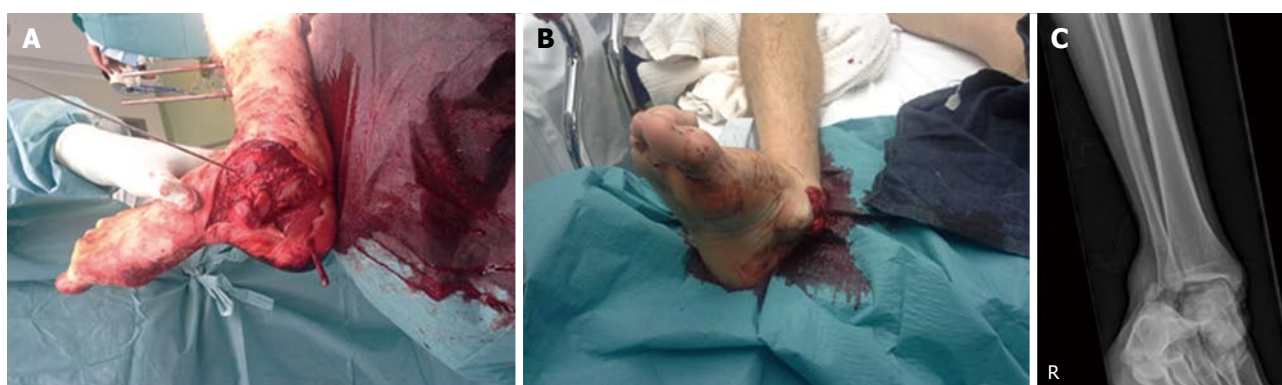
Initial trauma screening revealed a hemodynamically stable patient with a complicated (Gustilo type 3) subtalar joint dislocation of the right leg. A and B: Gustilo grade 3 complicated lateral dislocation of the right foot; C: Radiograph showing lateral dislocation of the subtalar joint.
